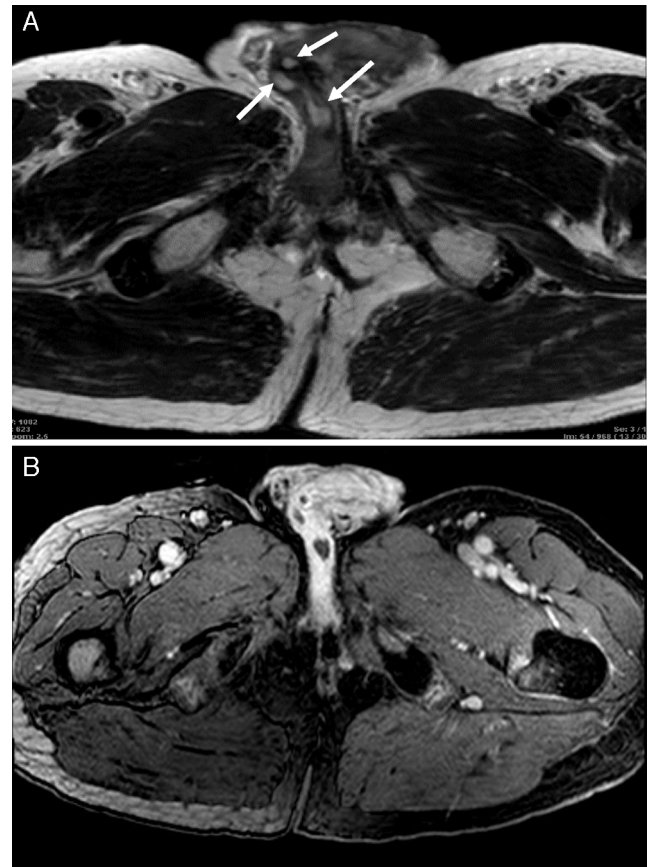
Penile magnetic resonance image. T1-weighted imaging shows lesions in the corpora cavernosa and glans (arrows) (A). After gadolinium administration, penile lesions shows peripheral enhancement (B).
